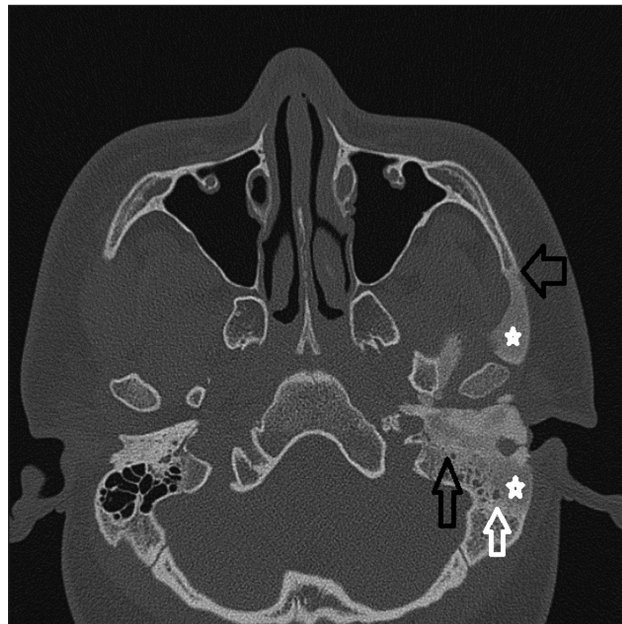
Axial High Resolution CT of the Mastoids: Diffusely sclerotic, expansile left temporal bone with a ground-glass appearance (*) and sharp transition to normal bone (wide black arrow). This involves the temporal component of the facial nerve canal with narrowing of the mastoid segment of the facial canal (thin black arrow). The mastoid air cells are opacified with fluid (white arrow).
